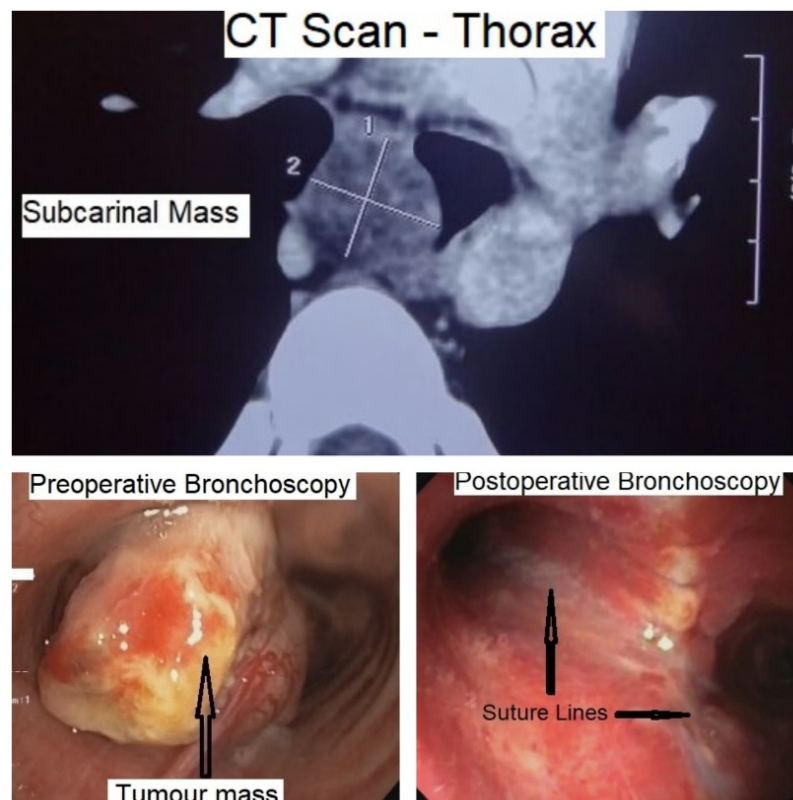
CT scan thorax and bronchoscopy
